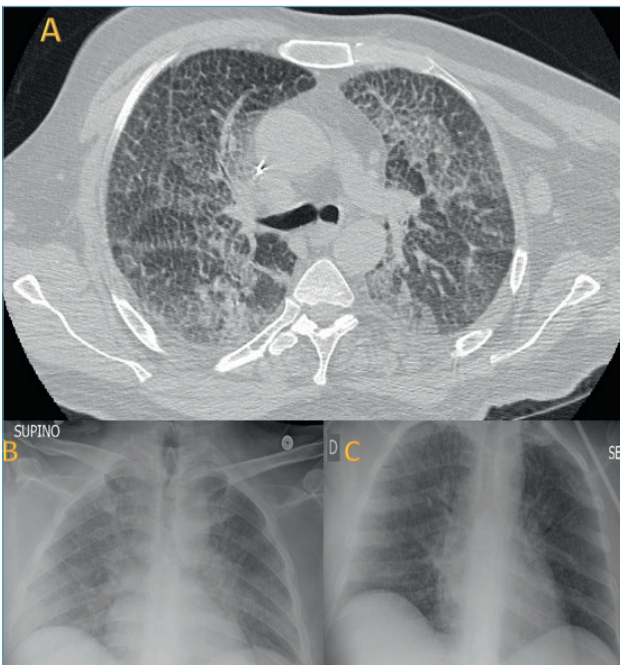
A) Thorax HRCT shows the radiological findings in type B Niemann-Pick Disease: bilateral smooth intra- and inter-lobular septal thickening and ground-glass opacities with crazy-paving pattern in the apical segment of the right lower lobe and in the left upper lobe. B) Chest radiographs before the WLL shows radiopacities areas with reticular thickening predominantly in the right lung. Note the improvement in C) after the first lavage.
